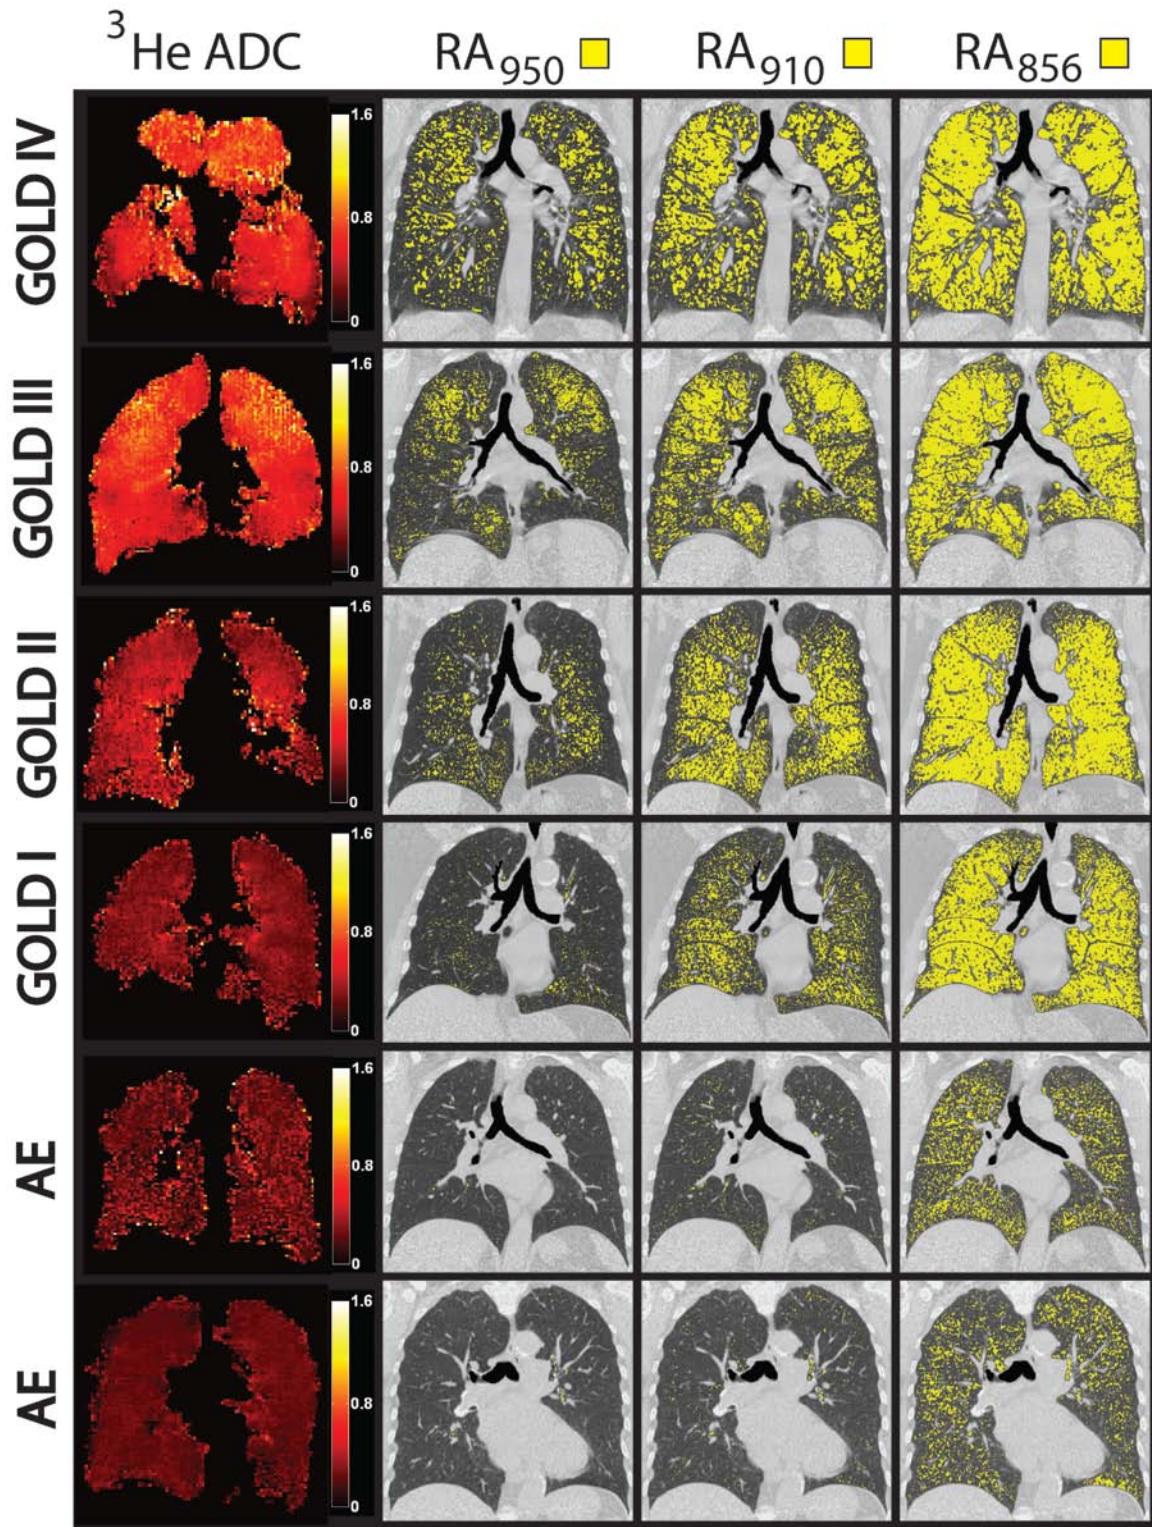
Coronal center slice ^3He ADC maps, CT images and Relative area (RA) Masks for HU thresholds.
